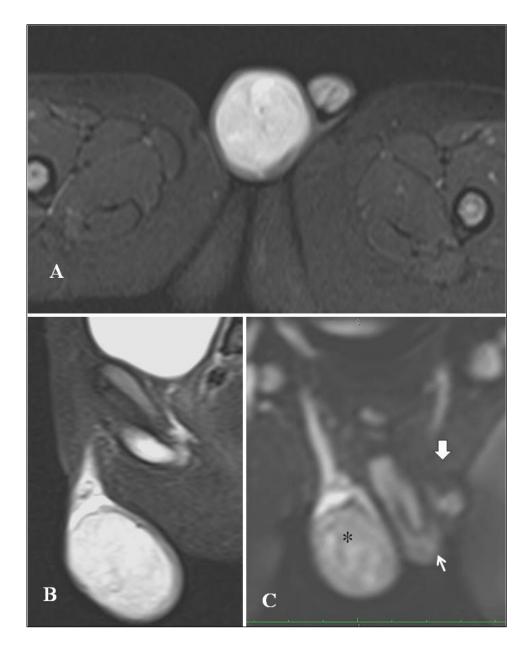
A 2-year-old boy with yolk sac tumor of right testis. MRI (A) Axial & (B) sagittal STIR images showing enlarged right testis with heterogeneously hyperintense signal. (C) DWI-MRI showing restriction, suggestive of aggressive/malignant tumor.[Note: * = right testis; small arrow = penis; thick white arrow = normal left testis].
